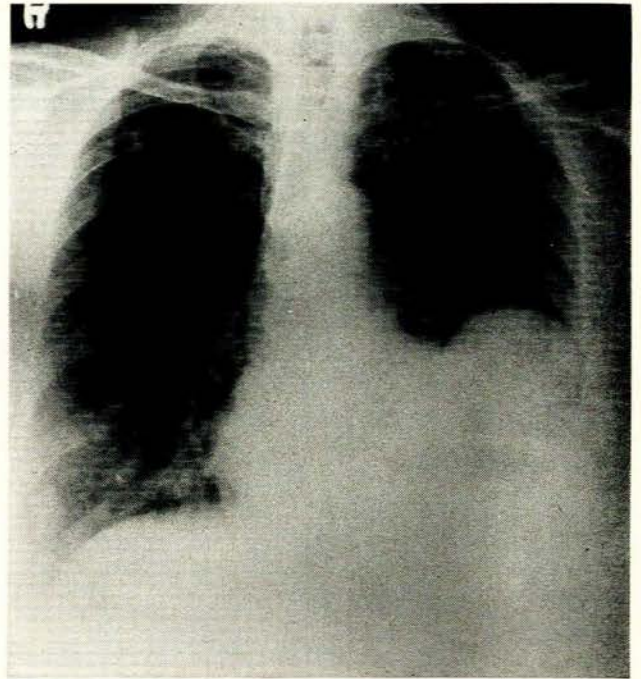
X-ray film of the chest reveals the large encysted and inspissated mass in the left lung field resting on the raised left leaf of the diaphragm. Metastases are now clearly visible in the right lung field, 4 May 1971.
